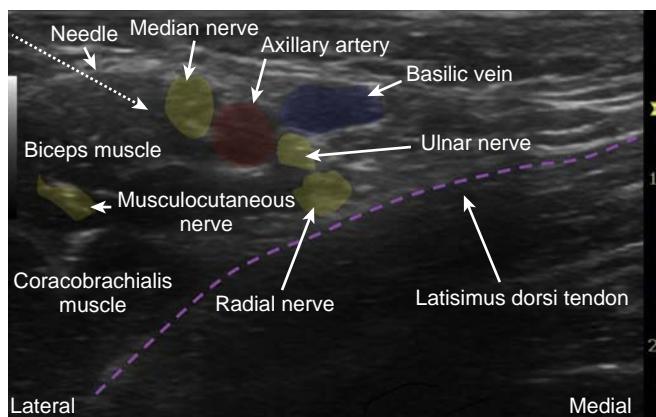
Ultrasound-guided axillary block imaging.
